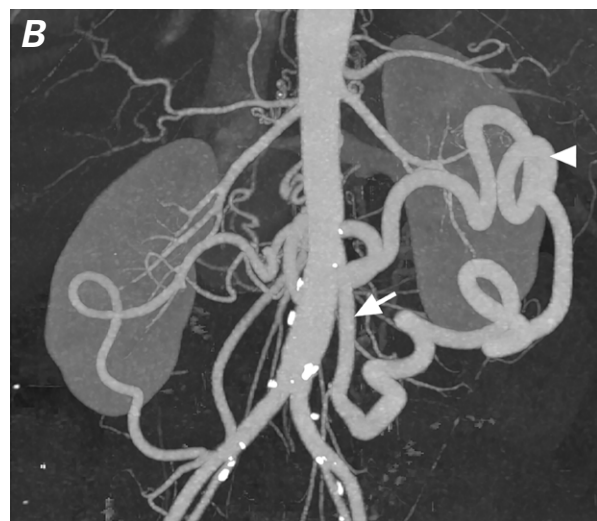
Patient 1. Computed tomographic angiograms show A) the occluded celiomesenteric trunk (arrowhead) in the sagittal view, and B) the hypertrophic inferior mesenteric artery (arrow) and mesenteric marginal arcade (arrowhead) in the coronal view (maximal-intensity projection).
